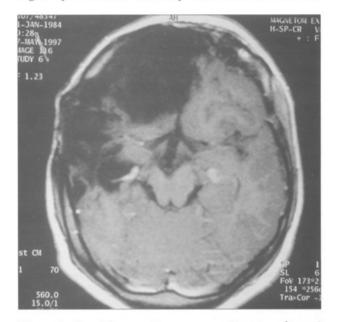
Cranial magnetic resonance imaging showed encephalomalacic changes in the right frontoparietal region, a porencephalic cyst in the right lateral ventricle, and atrophy of the corpus callosum.
